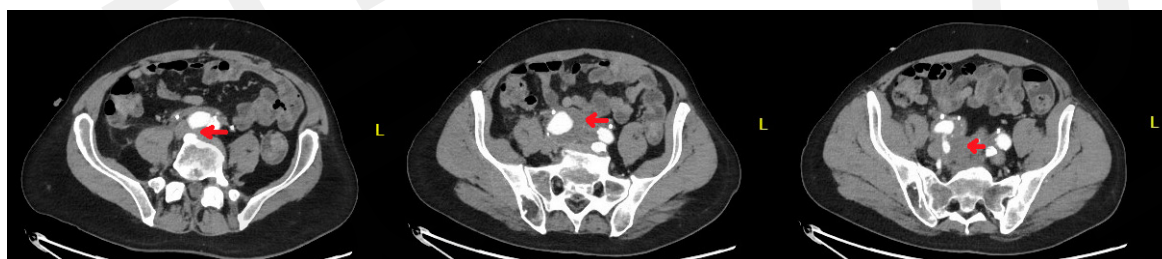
Image of the retroperitoneal space tumour in the described patient on abdominal and pelvic CT scan. The arterial phase. Red arrows – image of the tumor around the aortic bifurcation and iliac arteries
